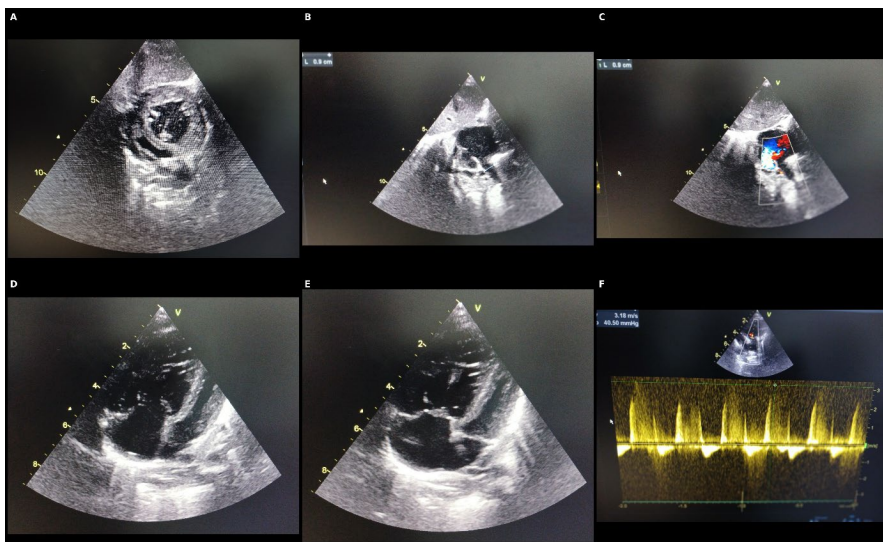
Transthoracic echocardiography findings in our patients with supracardiac total anomalous pulmonary venous return. (A): Parasternal short-axis view showing right ventricular hypertrophy. (B): Echocardiographic image showing a 9 mm atrial septal defect (ASD). (C): Color Doppler demonstrating a right-to-left shunt across the ASD. (D), (E): Apical four-chamber views showing dilation of the right cardiac chambers. (F): Continuous-wave Doppler demonstrating pulmonary regurgitation consistent with severe pulmonary arterial hypertension (PAH).
